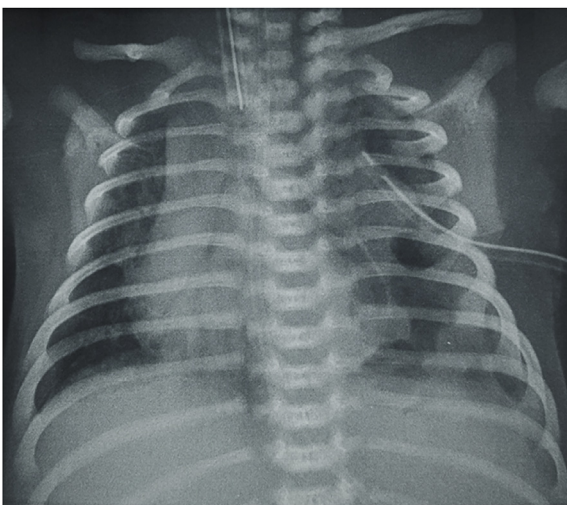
Plain film of the chest. Partial resolution of the hypertensive pneumothorax after left pleural tube insertion.
